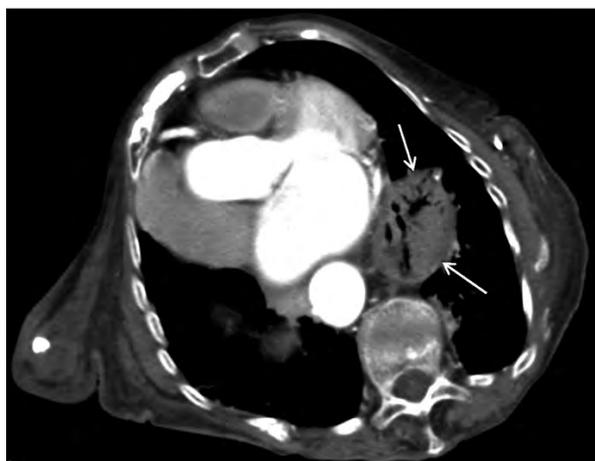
Computed tomography of the chest. Deformation of the chest, a large hiatal hernia (arrows), atelectasis in the right lung, and enlargement of multiple hilar and mediastinal lymph nodes
